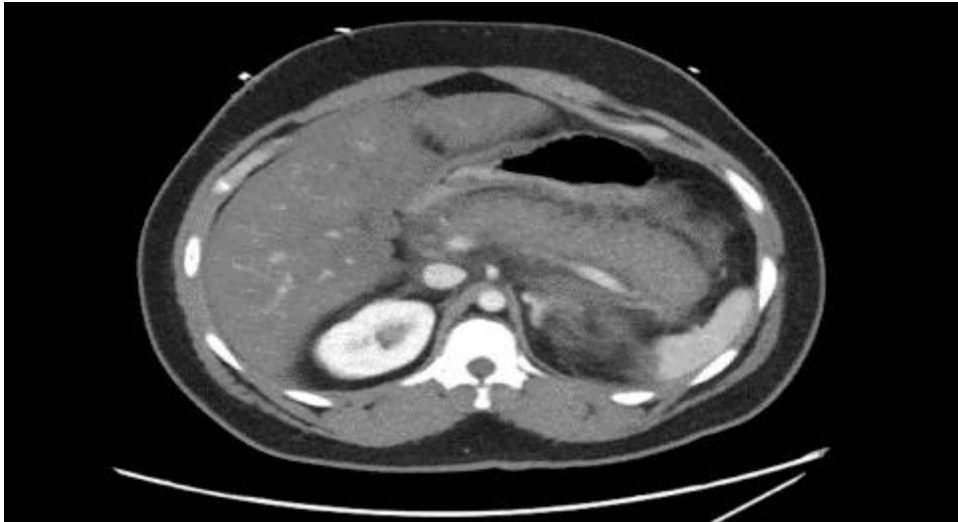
CT of abdomen and pelvis on admission demonstrated extensive hypoattenuation involving most of the pancreas representing acute pancreatitis.
